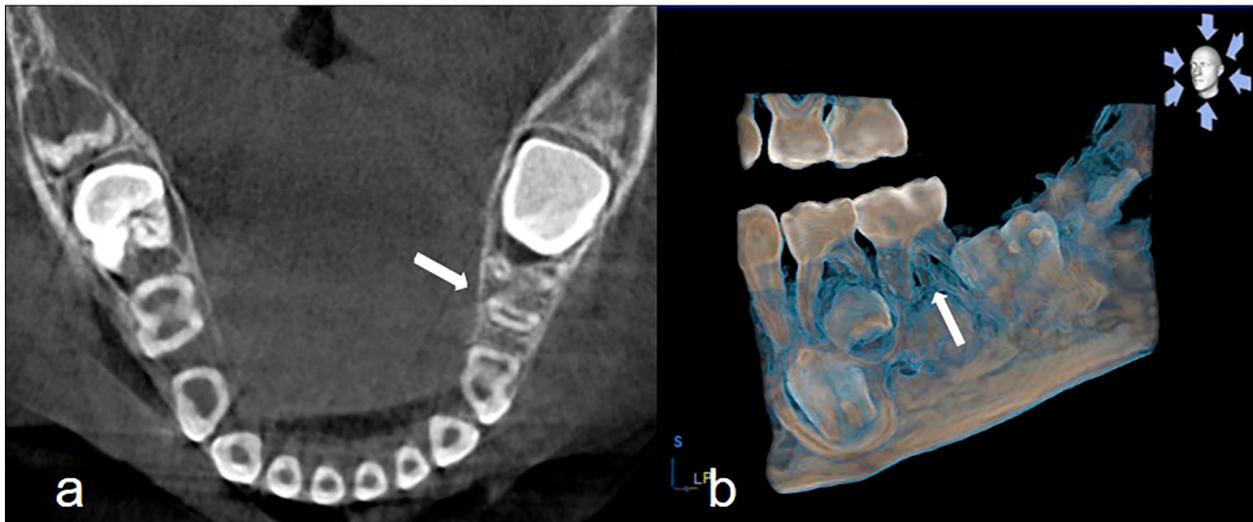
Cone beam computed tomography. a) Image of cross section corresponding to horizontal lines at the mid-level of primary mandibular molar roots; left primary mandibular first molar with three roots and one canal per root (arrow). b) Three-dimensional view of 3-rooted primary mandibular second molar (arrow).
